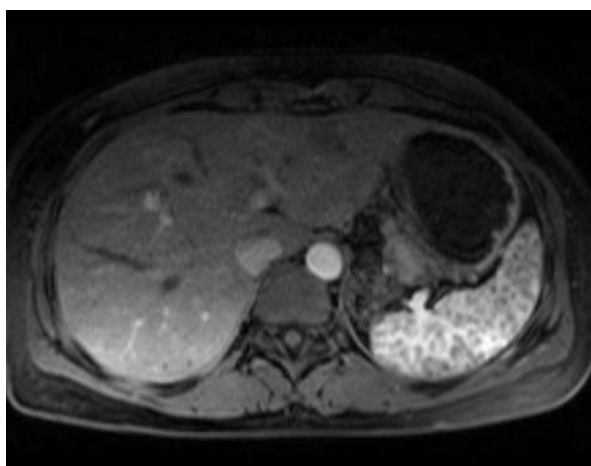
Case 1. 41 year old woman, MRI images. After administration of contrast the numerous, small, well-limited nodules in the spleen are visible
